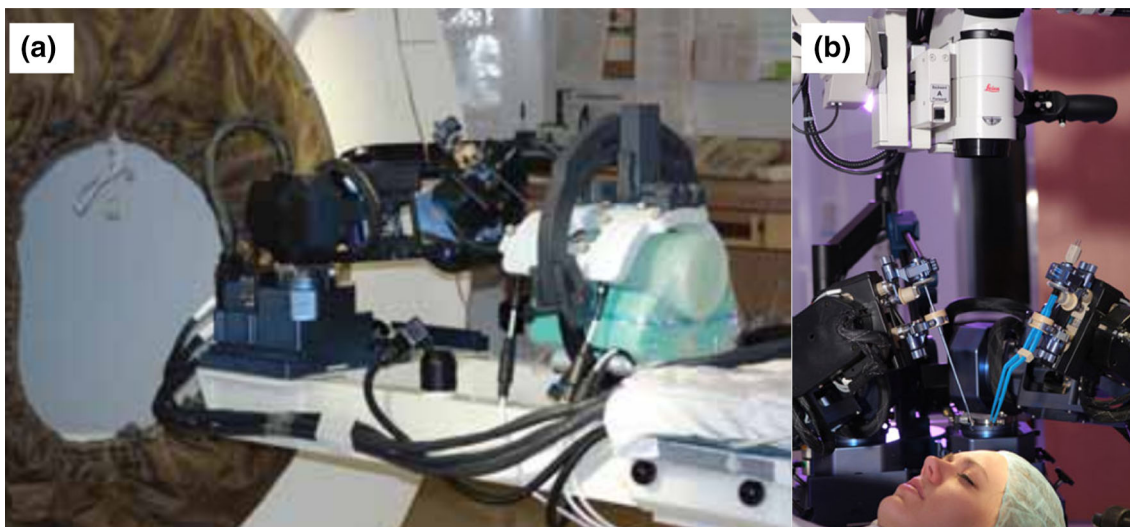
neuroArm on the top of extension table for stereotaxy inside the 1.5T MRI room.<sup>93</sup> (a) neuroArm inside the MRI scanner room; (b) The two dexterous manipulators of neuroArm.
